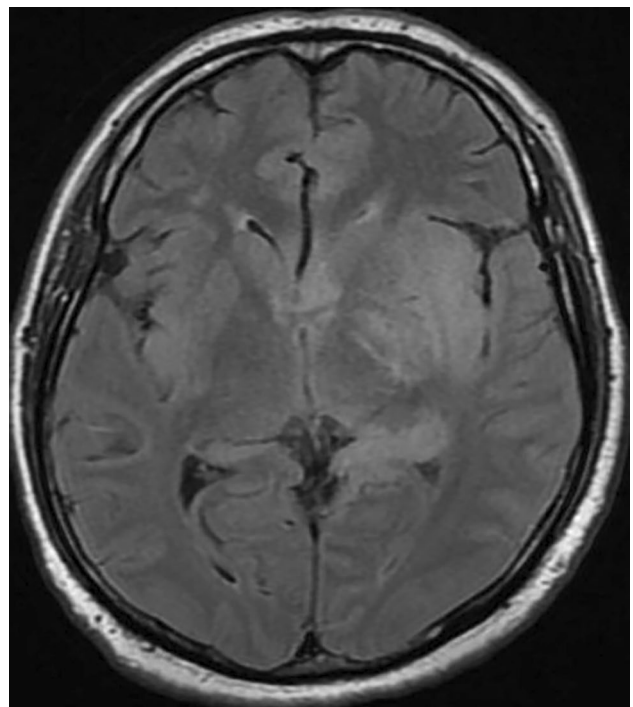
MR FLAIR image (done at admission) showing asymmetric hyperintensities involving both insula (left > right), left medial temporal and left frontal lobes
